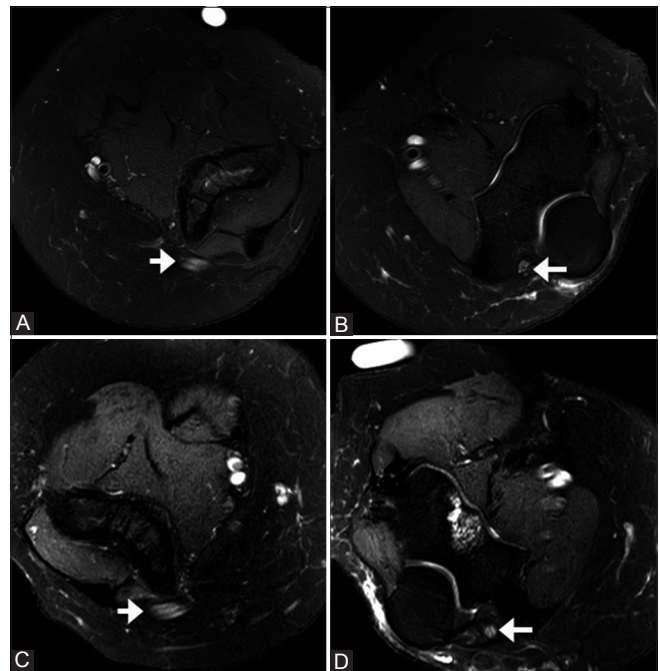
(A-D): Sequential T2-weighted SPAIR images proximal to (A) and within the cubital tunnel (B) show the hyperintense and flattened ulnar nerve on the left side (arrow). Similar findings are seen on the right side (C and D, arrow)
